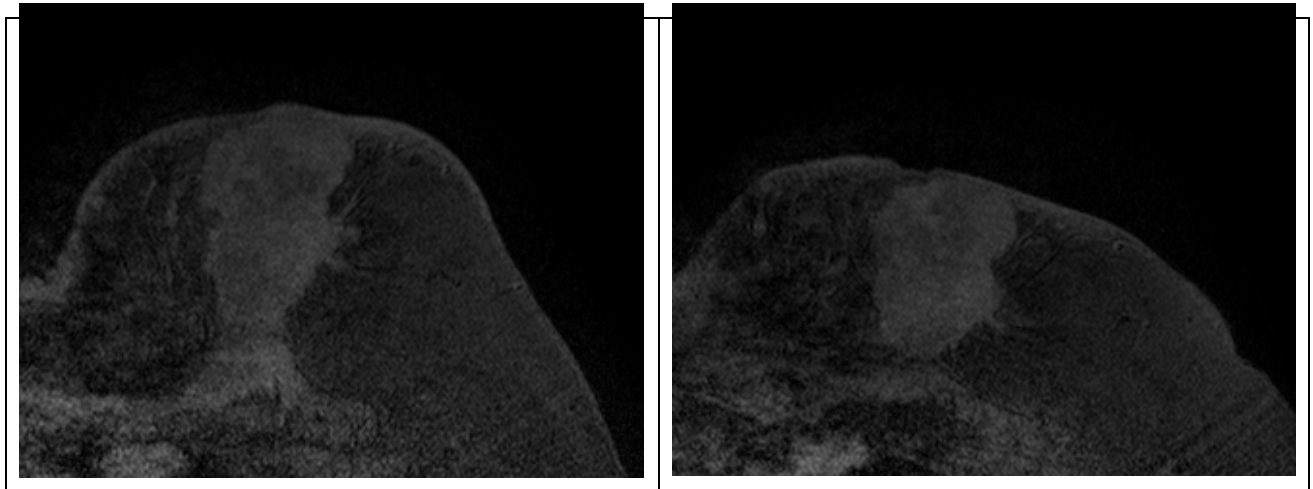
Example slices of an MR image obtained of a breast (a) before and (b) after compression as delivered by the clinical MIE chamber.
